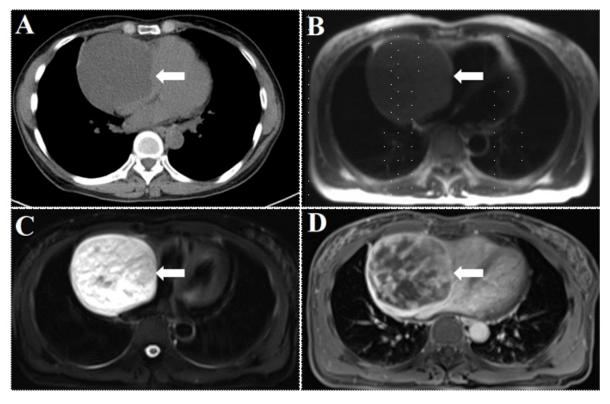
A 57-year-old woman complained of heart fatigue and tightness for four months. The blood examination and tumor marker had no obvious abnormalities. Chest CT indicated a pericardial mass with a low density (A). Cardiac magnetic resonance imaging (MRI) showed this lesion had low signal on T1WI image (B) and heterogeneous high signal on T2WI image (C). Also, it had obvious delay enhancement (D). A malignancy was suspected.
